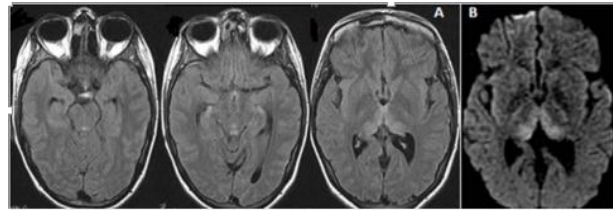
Brain MRI in FLAIR sequence (A), diffusion (B) showing symmetric and bilateral hyper signal lesions in the paramedian region of the thalamus, mammillary bodies, and periaqueductal region.
